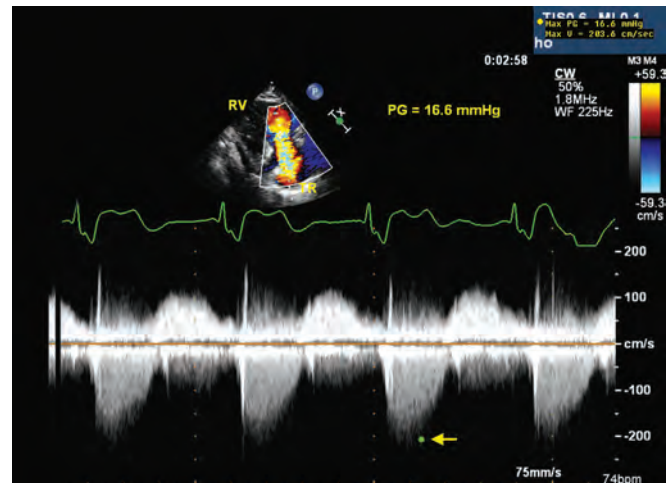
Color Doppler guided continuous wave recording shows a low gradient across the TV consistent with normal PA pressure.
